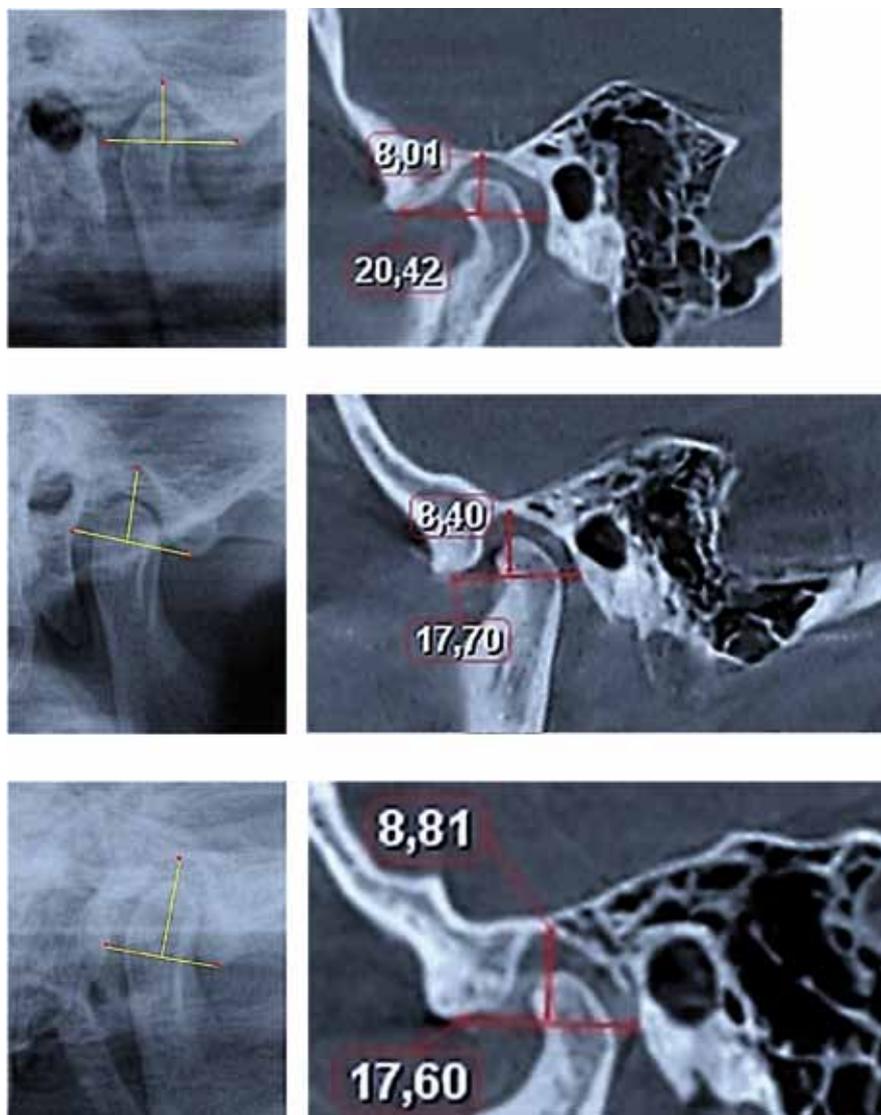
X-ray image (a, c, e) and tomogram (b, d, f) of the TMJ in people with physiological occlusion and protrusive (a-b), mesotrusive (c-d) and retrusive (e-f) position of the front teeth
